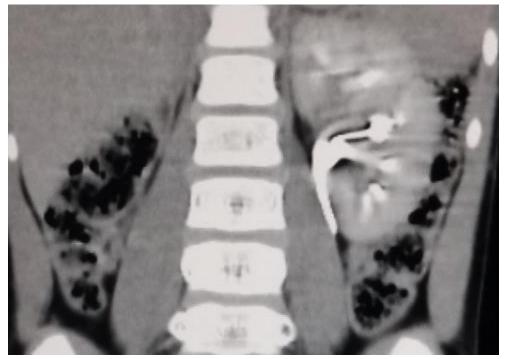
is a coronal reformatted contrast enhanced computed tomography showing the left kidney excreting into the pelvic and the proximal ureter(as shown in the image) and beyond (not shown).
